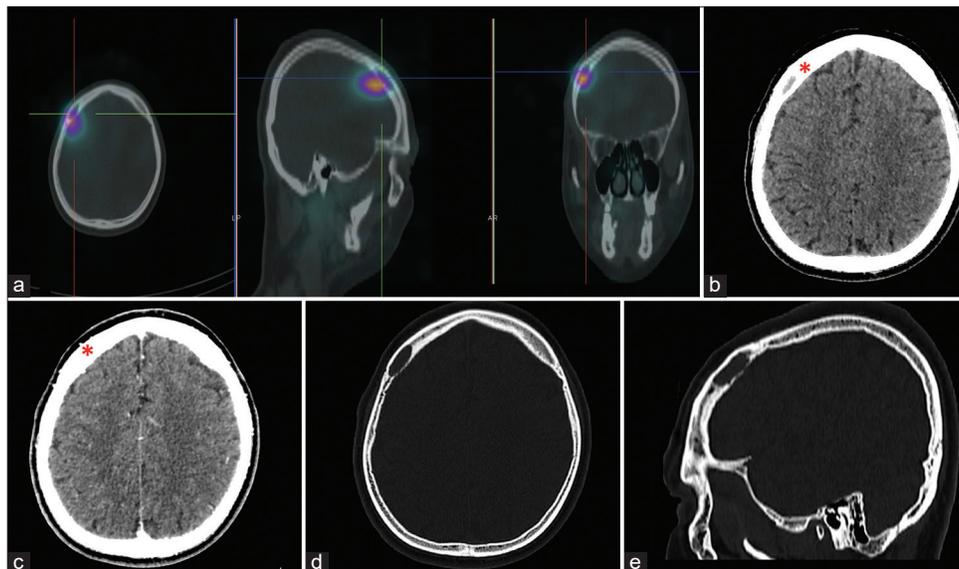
(a) Axial, sagittal, and coronal images showing the focus of intense tracer accumulation in the right frontal bone on metaiodobenzylguanidine I-123 scintigraphy, (b) axial image of plain cranial computed tomography (CT) showing the well-defined, expansile, and elongated lytic lesion in the right frontal bone (red asterisk) measuring 2.3 × 2.3 × 0.7 cm, with enhancement on contrast (c), (d and e) axial and sagittal view of the cranial CT bone window showing the lytic lesion in the right frontal bone.
